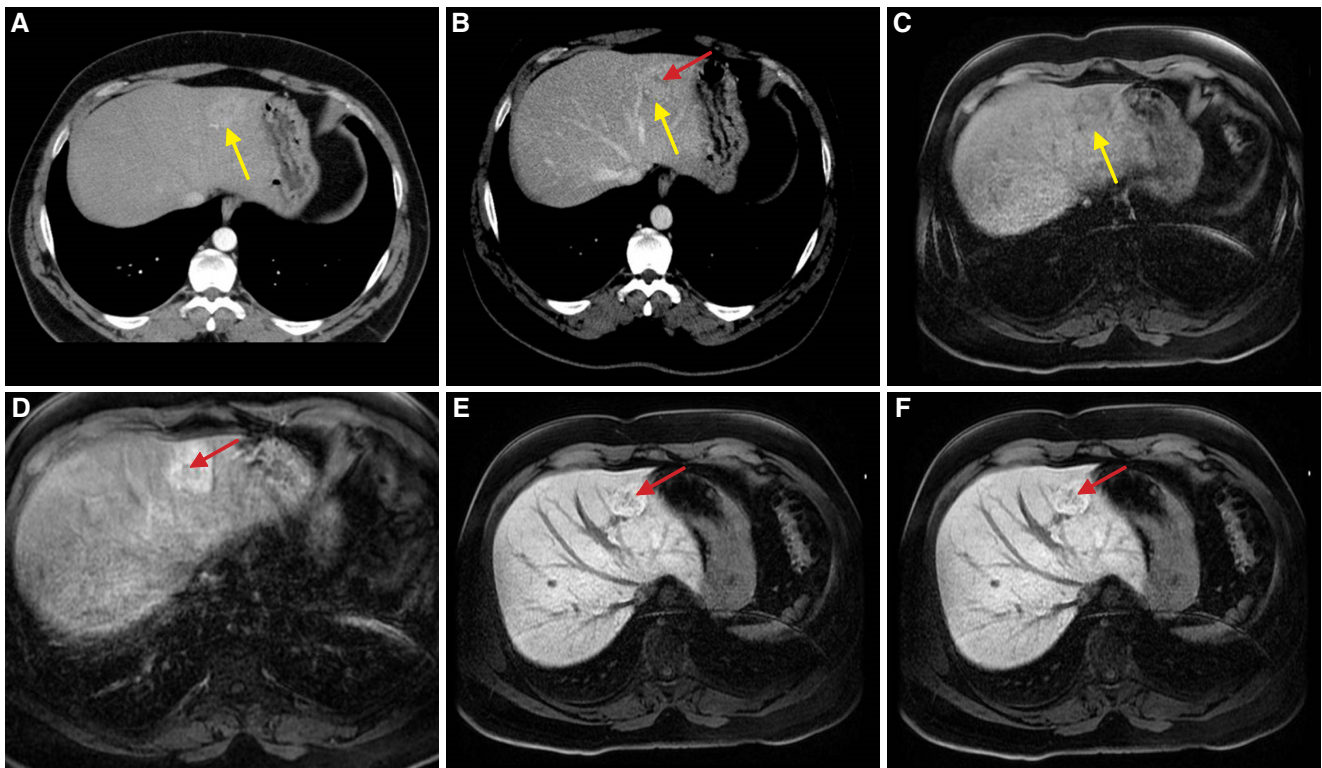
Computed tomography: axial planes obtained in arterial phase (A) and portal phase (B). Focal lesion in left hepatic lobe (yellow arrow) shows enhancement in the arterial phase (A) and is isodense in the portal phase (B) with central scar (red arrow). Magnetic resonance imaging: liver acquisition with volume acceleration dynamic sequences in axial planes: noncontrast phase (C), arterial phase (D), hepatocyte phase (E) and portal phase (F). Focal lesion is hypointense in noncontrast phase (C) with enhancement in arterial (D) and hepatocyte phases (E), with central scar. Lesion is isointense in delayed phase (F). Lesion shows typical radiological findings of focal nodular hyperplasia
